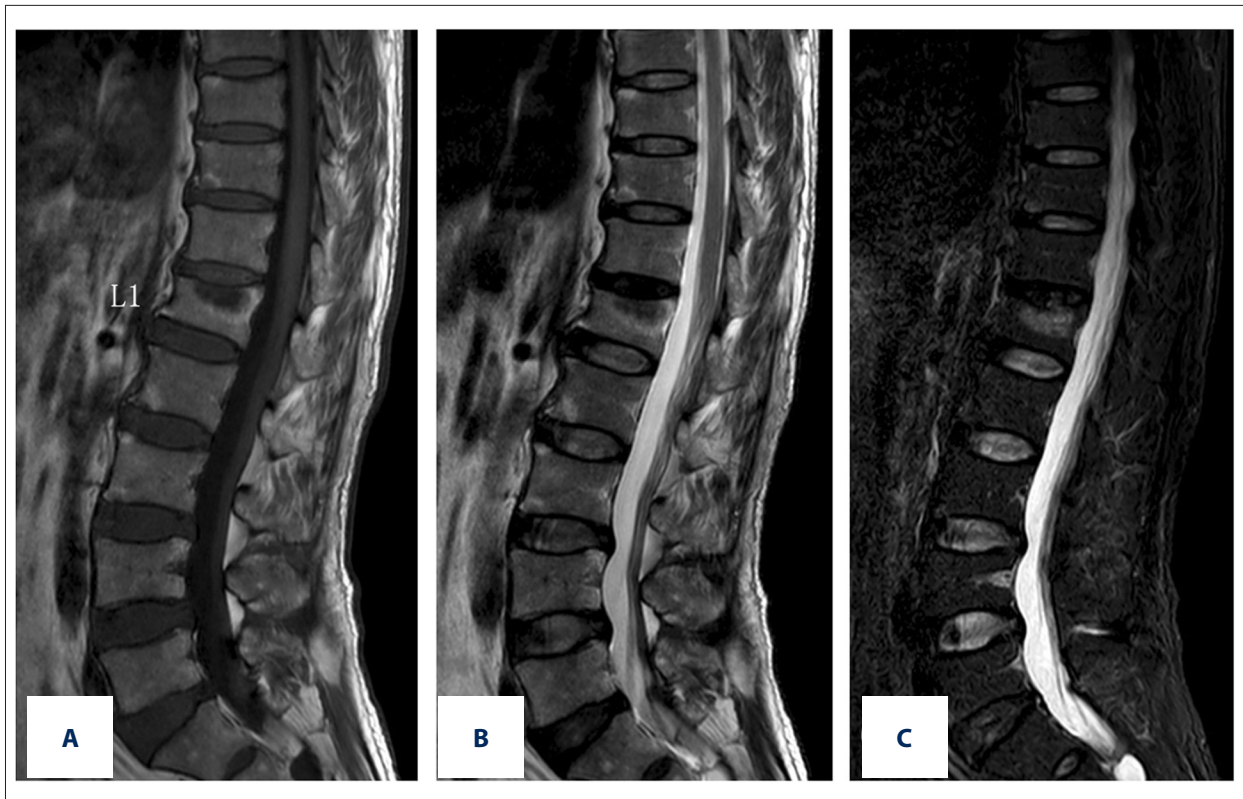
On sagittal MRI images, vertebral body bone marrow surrounding the node was characterized by low-intensity signal on T1-weighted sequences (A), high-intensity signal on T2-weighted sequences (B), and especially high intensity on STIR sequences (C). The appearance of the node was typical and appears as a small pocket in the vertebral body with continuation into the disc through the vertebral endplate (C).
